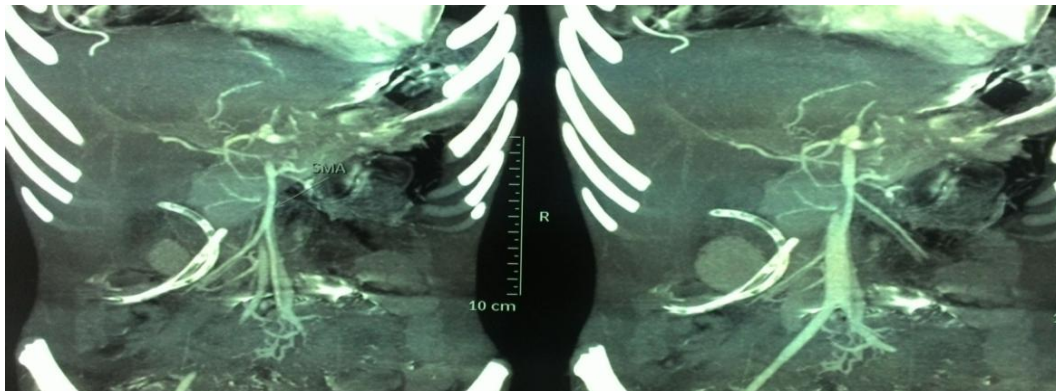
CT film showing the foreign body
